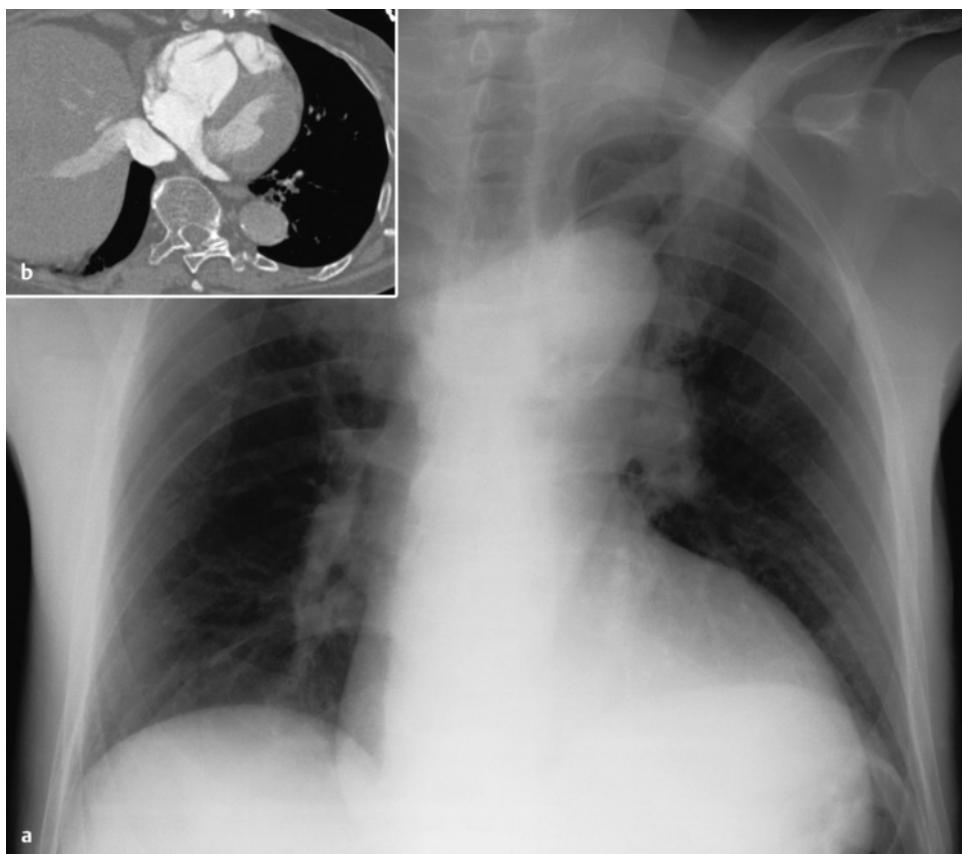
Pressure overload in severe hypertension. Significantly enlarged left heart with pronounced elongation of the aorta along the right cardiac border. There are no signs of decompensation. Deep cardiac waist (a). CT demonstrates hypertrophy of the left ventricular wall (b). Note the significant congestion in the hepatic veins indicative of left heart failure.
